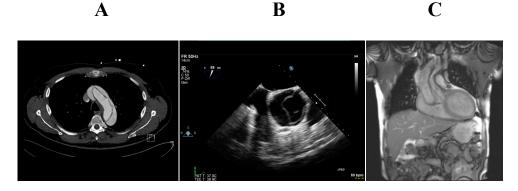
ATAAD visualised on A: computed tomography; B: transoesophageal echocardiography; and C: magnetic resonance imaging. Courtesy of Dr Carl Meurling, Department of Heart and Lung Medicine and Dr Ellen Ostenfeld, Department of Medical Imaging and Clinical Physiology, Skåne University Hospital, Lund, Sweden.
